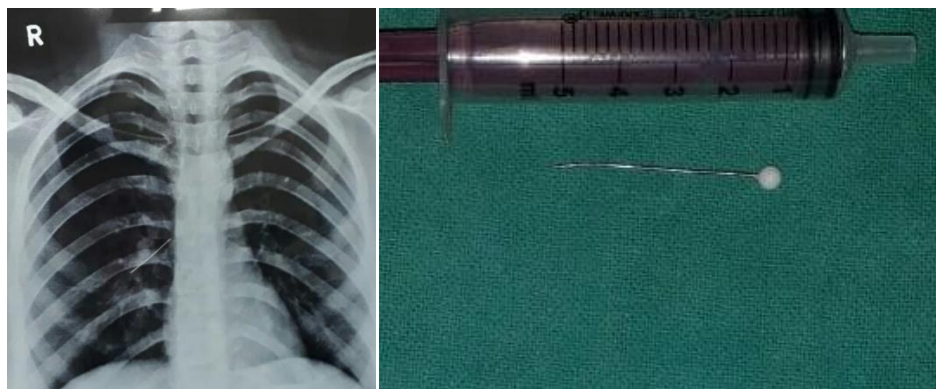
Xray chest P/A view showing Pin in the right bronchus along with the removed pin
